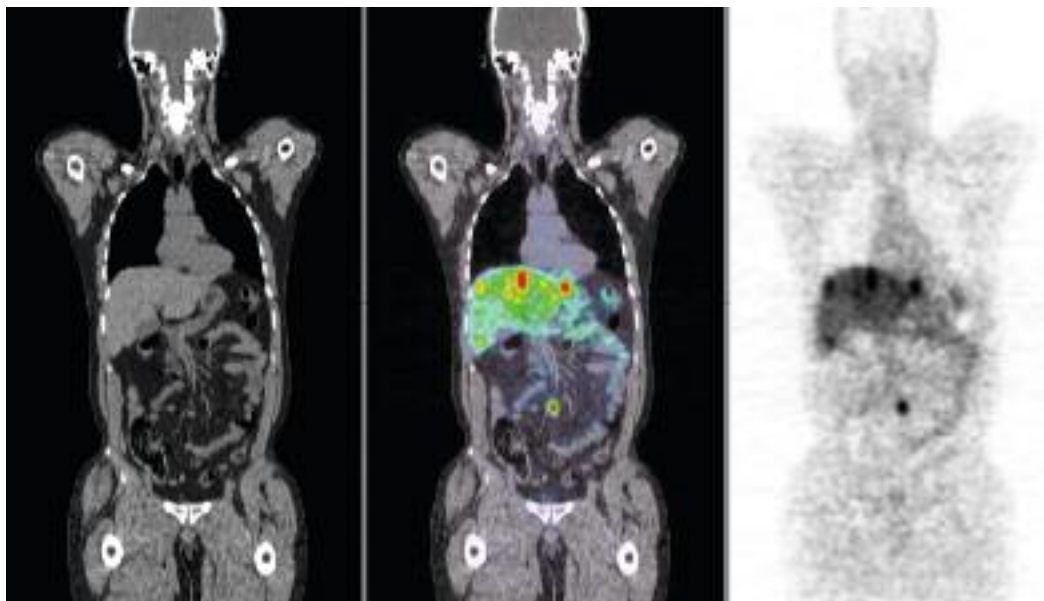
^{68}Ga -DOTATOC PET-CT of a patient with carcinoid syndrome, diffuse liver metastases and a small unique mesenteric tumour.
